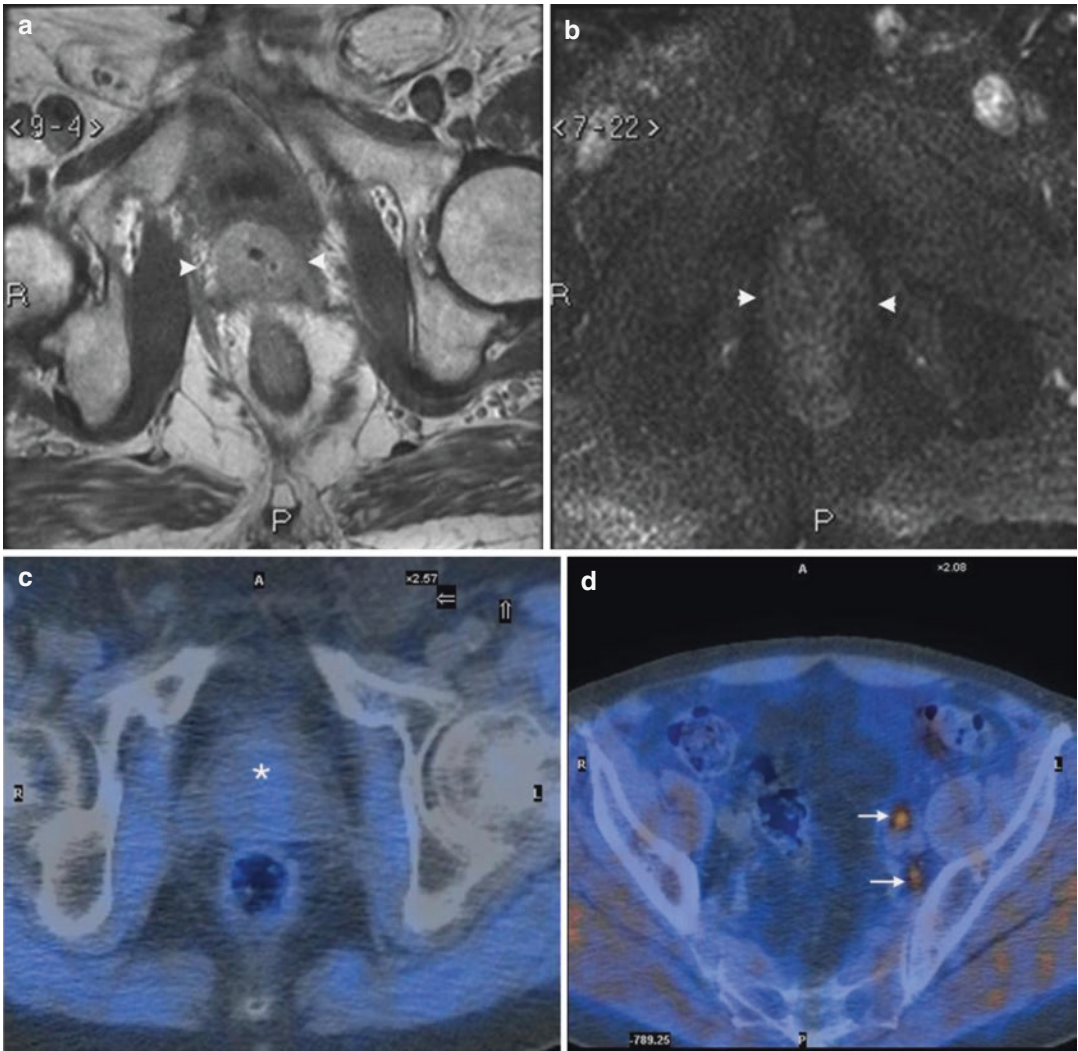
A 78-year-old man with rising PSA after radiotherapy. (a) MR T2-weighted axial image shows low signal intensity of the irradiated tissue (*arrowheads*). (b) DWI image shows normal low signal intensity of prostate
